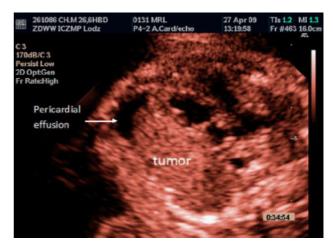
Echocardiographic image of teratoma
